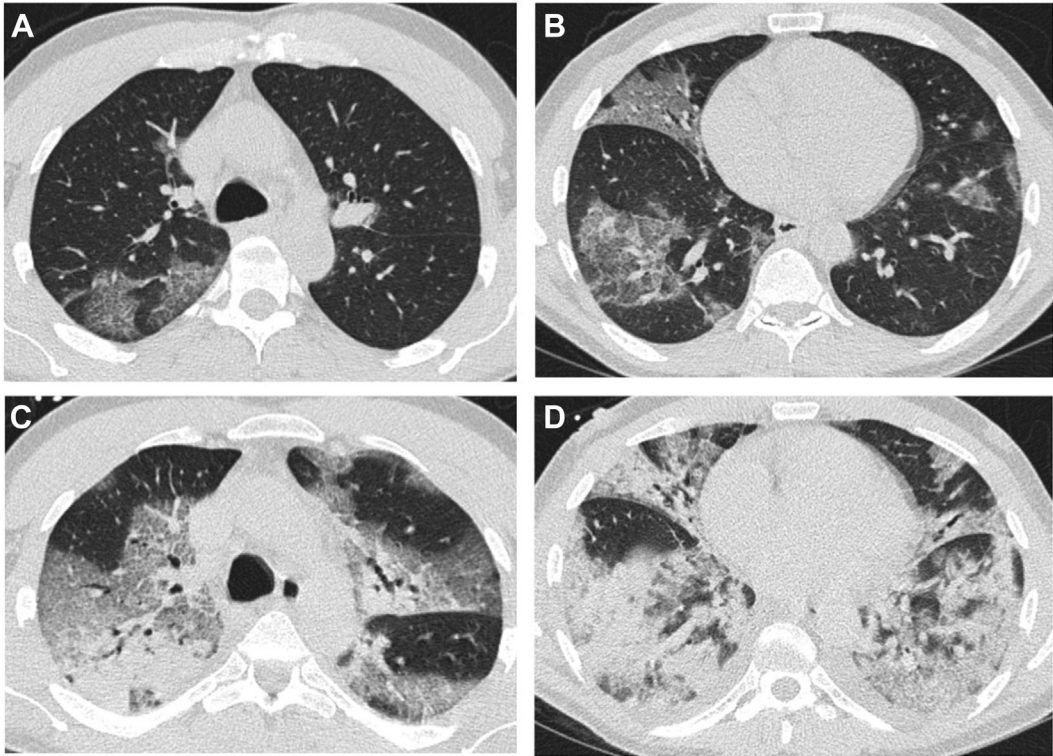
A-D, CT chest image at presentation and follow up. A and B, CT examination performed at presentation to the ED, 12 days after the start of symptoms, reveals bilateral patchy, slightly nodular ground-glass opacities in a peripheral and basilar distribution. C and D, Follow-up CT performed 8 days later reveals marked worsening of the pulmonary opacities that now are largely consolidated.
